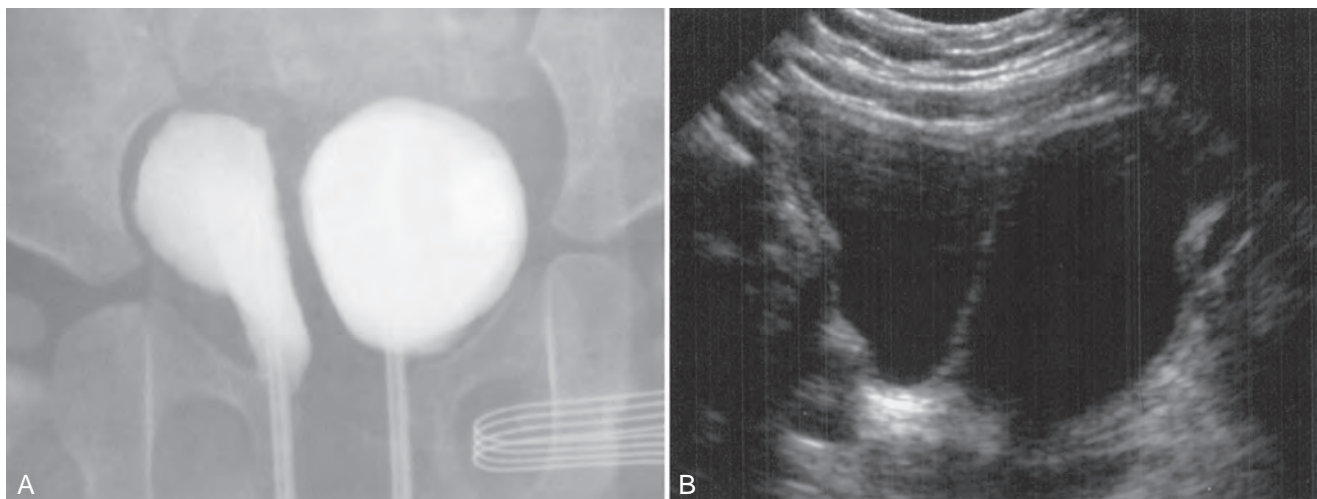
Complete bladder duplication. A, Vesicoureterogram image of complete bladder duplication with catheters inserted into each individual urethra. Note the size discrepancy. B, Ultrasound image of the same patient.
